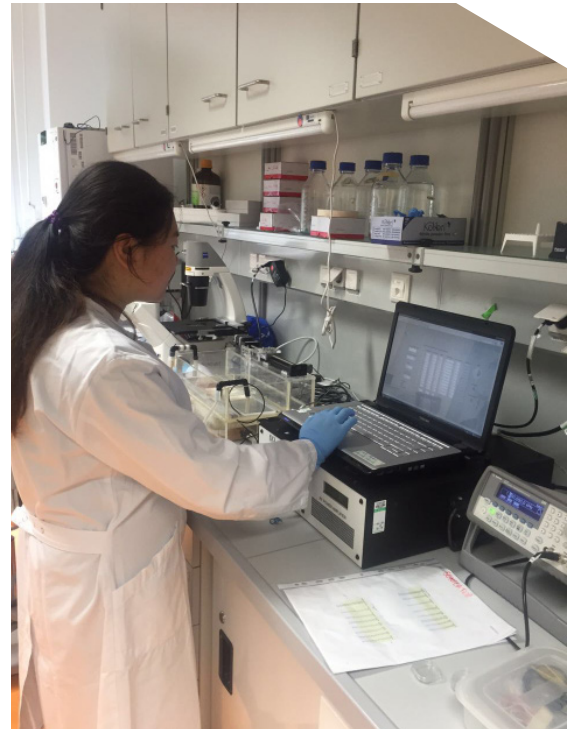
Focused ultrasound workstation in cell laboratory.
